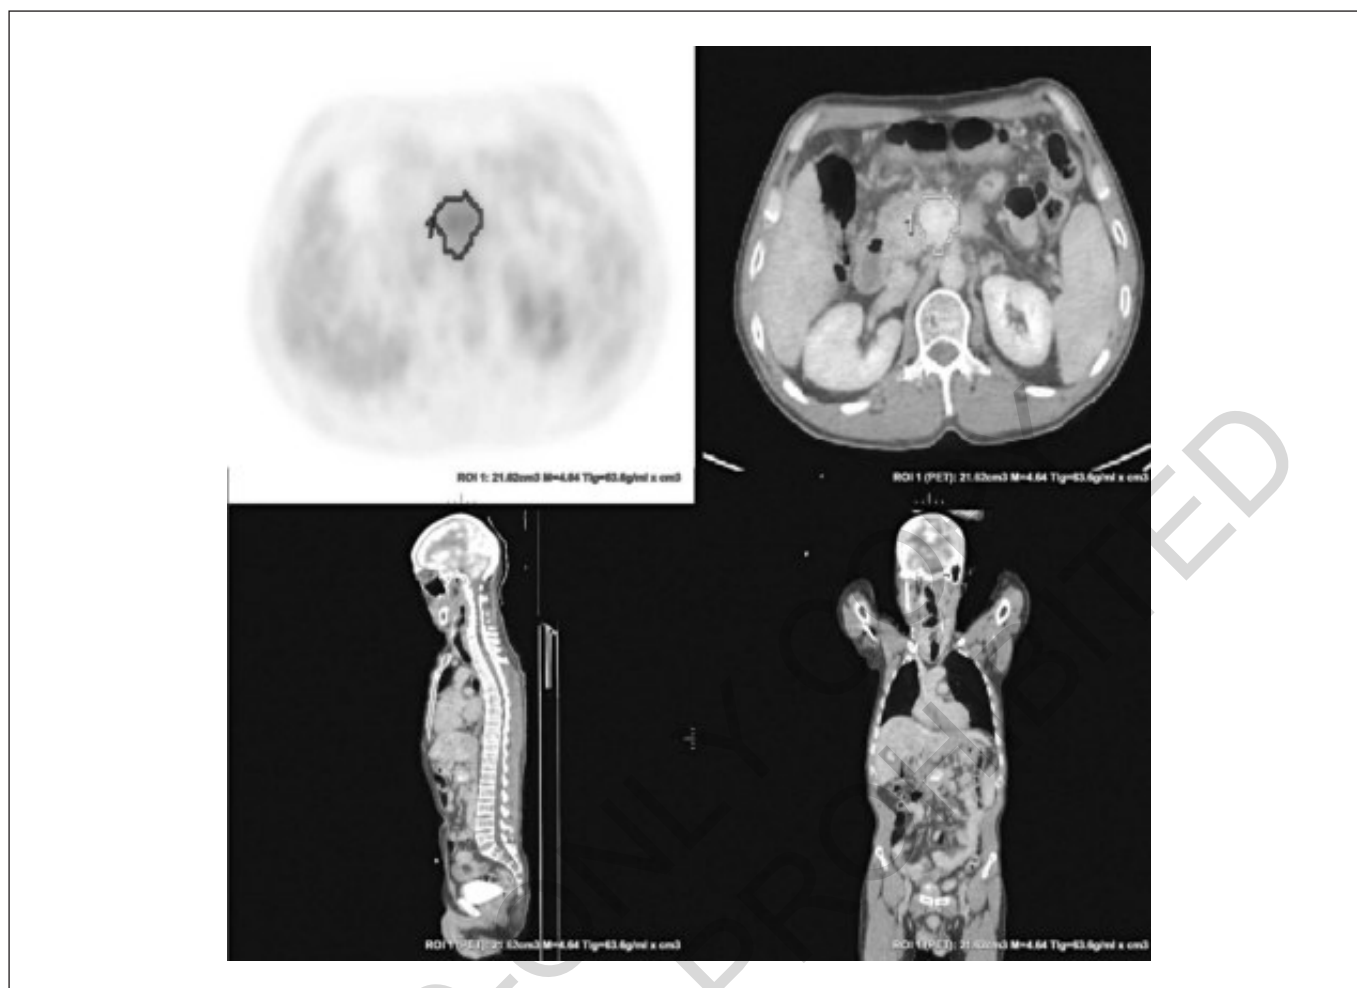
A) 63-year-old female patient with pancreas adenocarcinoma; primary tumors MTV: 11,14 cm<sup>3</sup>, primary tumors TLG: 59,0 g/ml.cm<sup>3</sup>, primary tumors SUVmax: 10,57.
